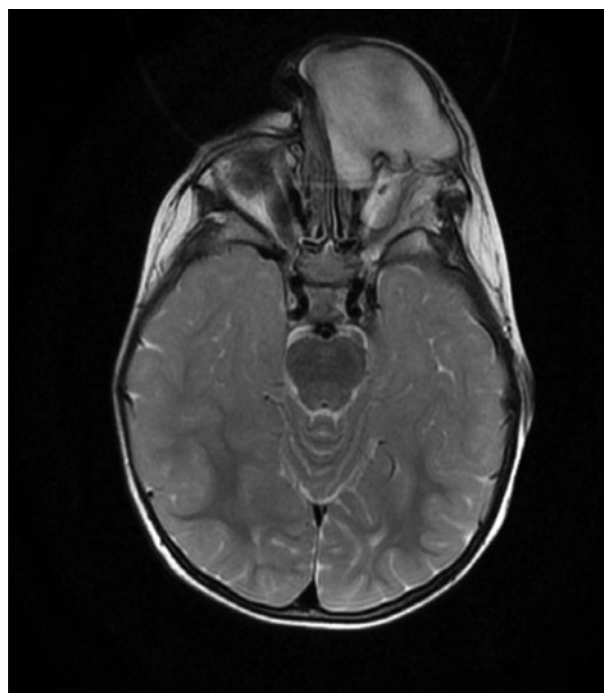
Axial plane magnetic resonance imaging (T2-weighted post-contrast) of face.
